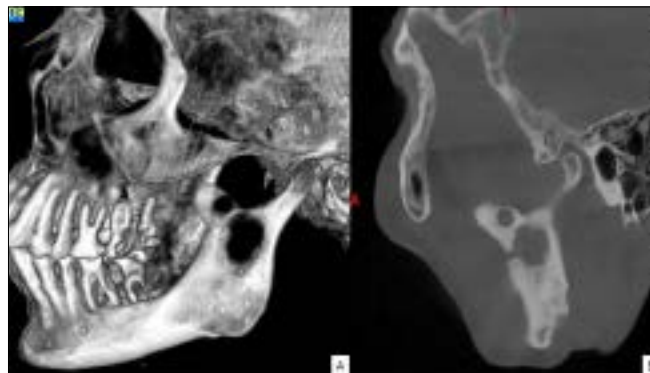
CBCT of the patient revealing two solitary well defined lesions measuring 13mm and 6.7mm in the ramus and coronoid process of mandible respectively.
